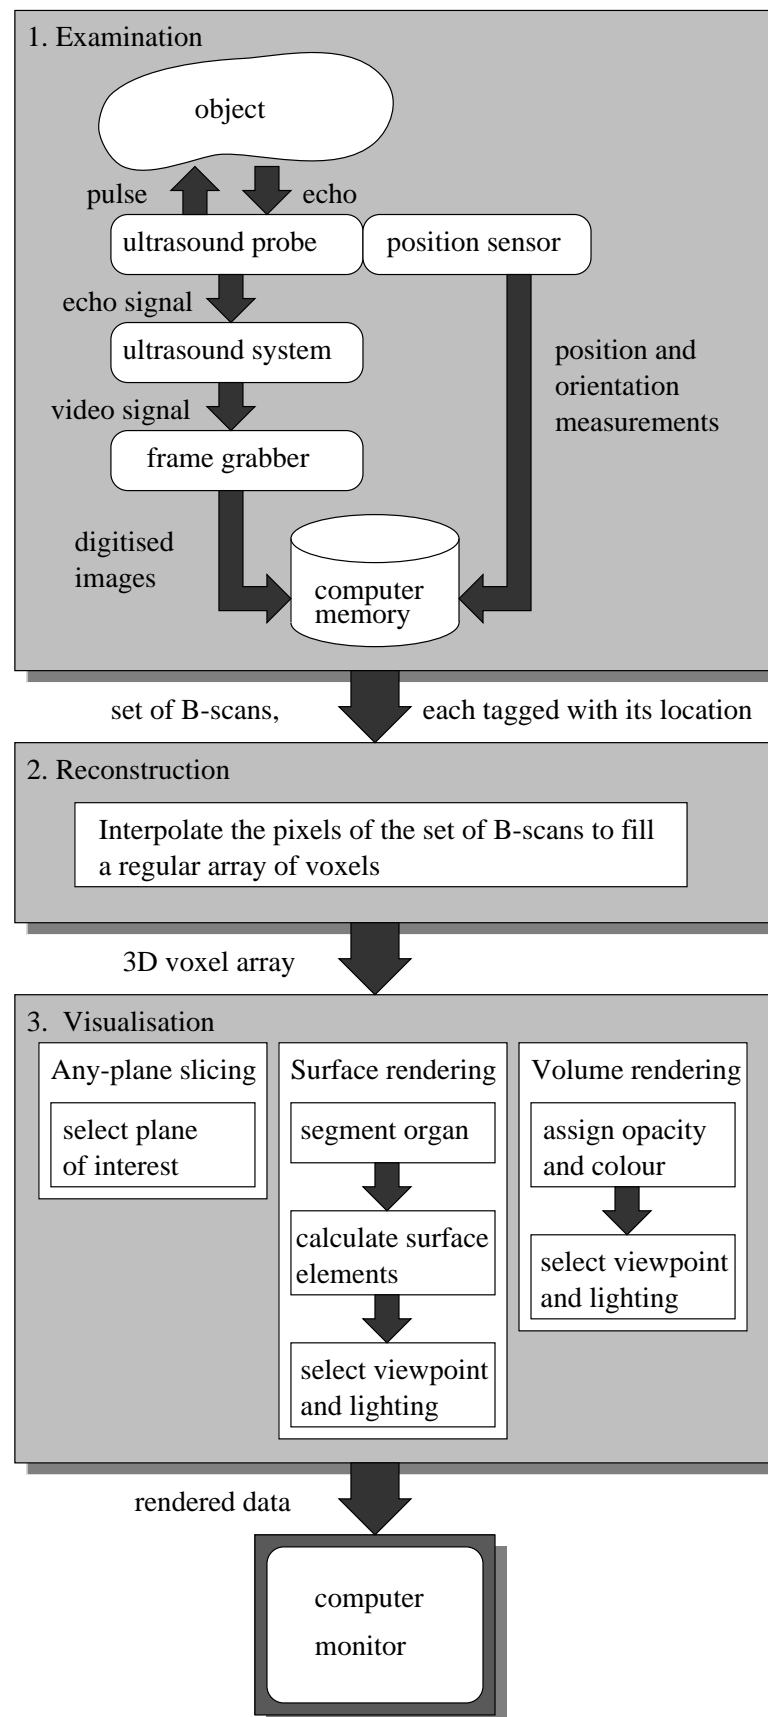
Data paths of 3D freehand ultrasound imaging.
